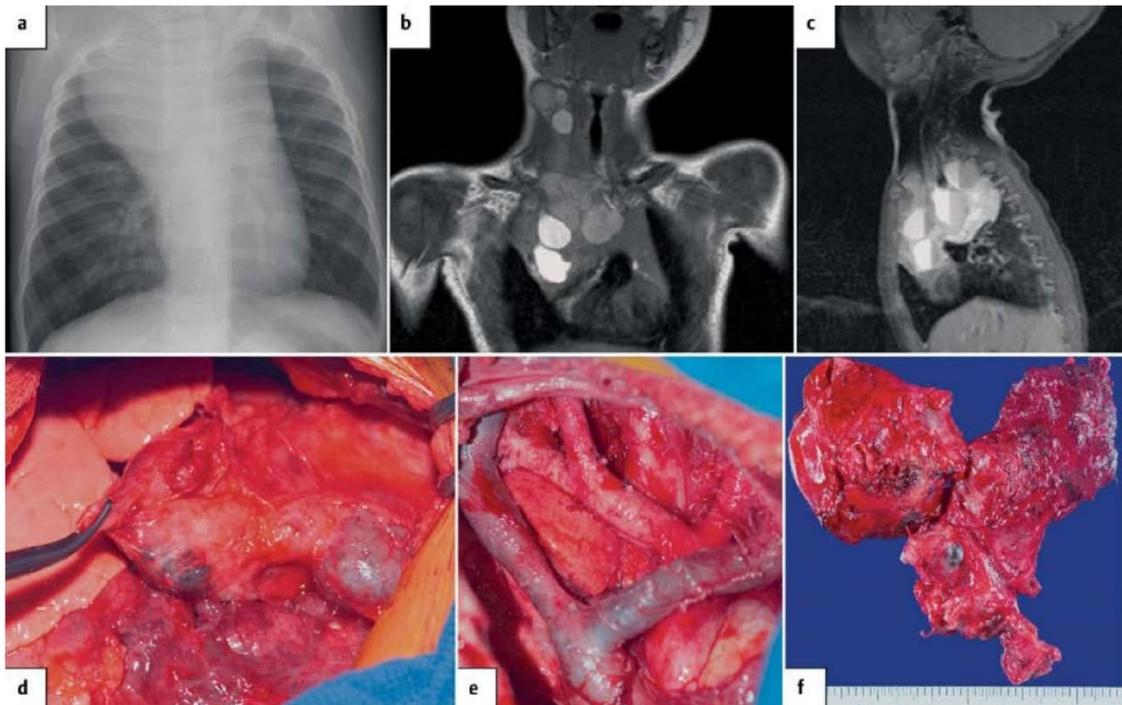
a,b,c,d,e,f. A child 9 months old with increasing shortness of breath, recurrent vomiting, livid discoloration and swelling of the left arm, (a) Chest X-Ray showed a massive widening of the upper mediastinum, (b,c) magnetic resonance imaging showed a mixed vascular malformation located in the entire upper mediastinum and the right side of the neck, (d,e,f) surgical resection was performed under strict protection of vital structures.
